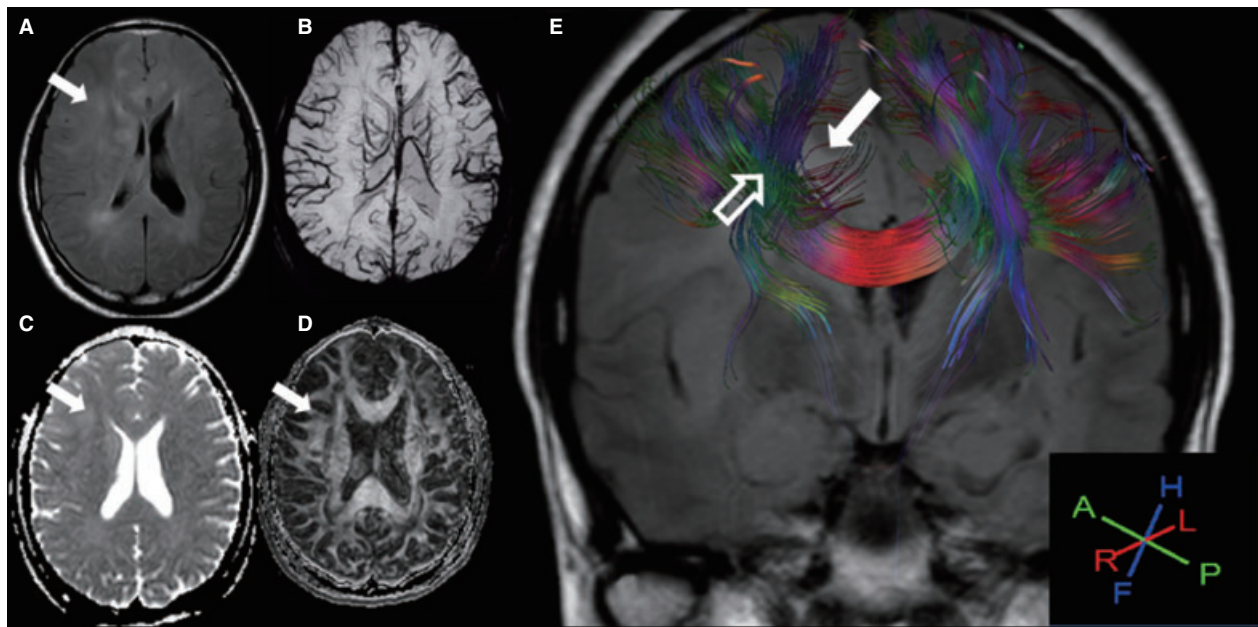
The potential pattern of a white matter (WM) fiber tract was altered by a low-grade glioma in a 37-year-old man, who was diagnosed from a biopsy of the right frontal lobe. (A) Axial T2FLAIR shows that the tumor (white arrow) exerts a mild mass effect. The hyperintensity lesions are diffuse in the right frontal lobe and the bilateral corona radiata. (B) Axial three-dimensional FFE Venous BOLD shows a homogenous signal in the right frontal lobe and the bilateral corona radiata without hemosiderin inside the tumor. (C) and (D) The ADC and fractional anisotropy (FA) maps show increased ADC and decreased FA in the right frontal lobe. (E) 3D tractography registered with the FLAIR shows that the high T2 signal (white arrow) spreads along the WM tracts (hollow arrow).
